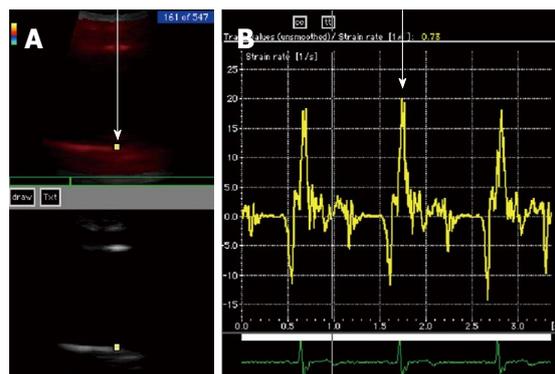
Measurement of the strain rate of the ascending aorta by tissue Doppler echocardiography. A: A region of interest (arrow) was identified on the ascending aortic wall; B: Strain rate (arrow) was recorded and the peak value during initial contraction was measured by averaging the systolic peak of three heart beats.
